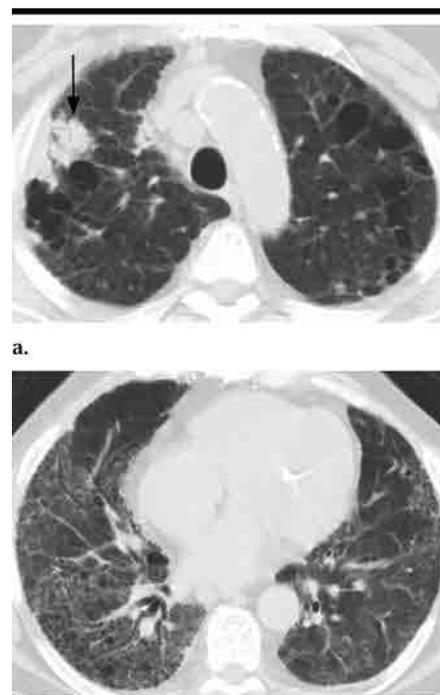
Transverse thin-section CT images in a 72-year-old man with UIP complicated by large cell neuroendocrine lung cancer, which was detected incidentally on chest radiograph (not shown). (a, b) Subpleural mass in right upper lobe (arrow) is evident at two levels, with extensive, predominantly basal honeycombing.
